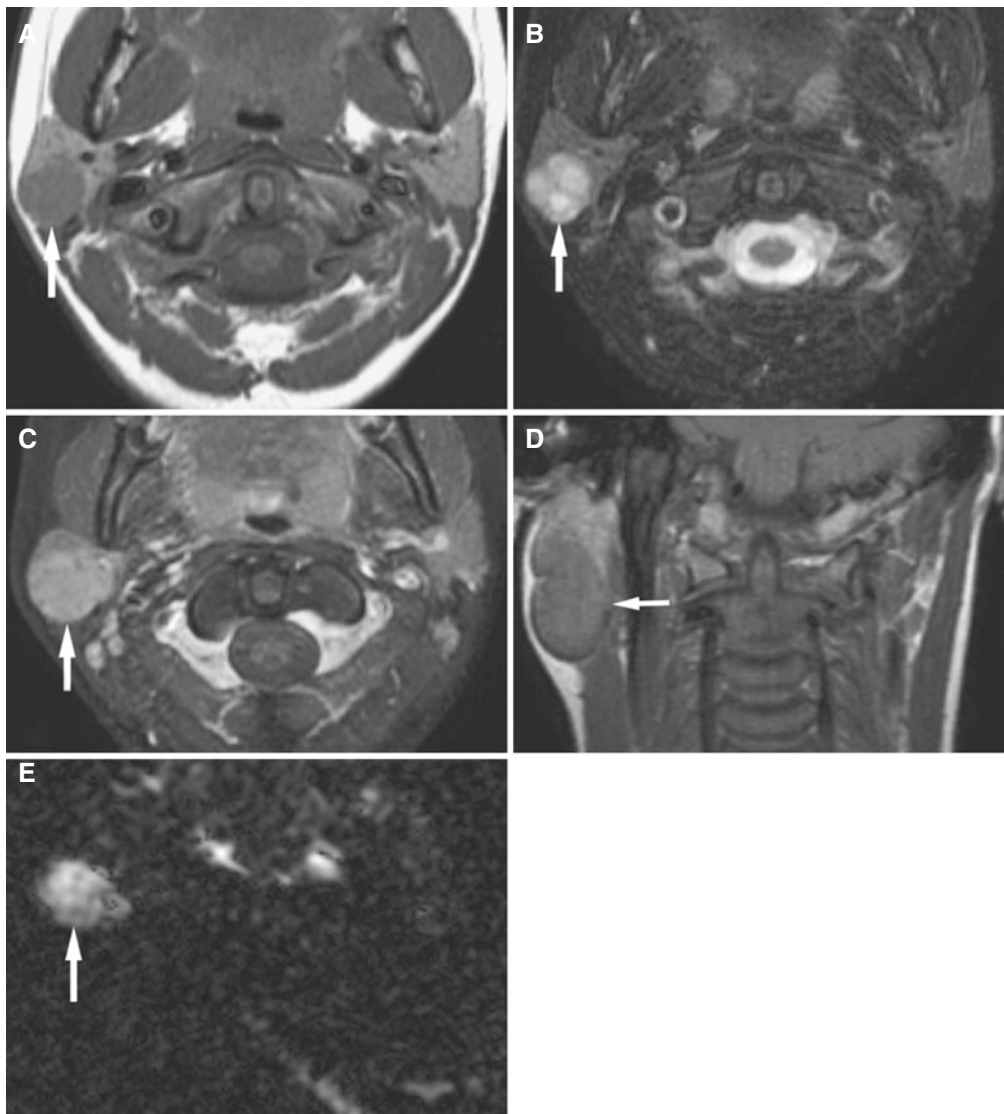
Parotid acinic cell carcinoma; 11-year-old female with painless swelling of the right parotid gland that did not respond to antibiotic treatment. (A) Axial T1-weighted MRI shows well-defined low-to-intermediate signal mass in the posterior portion of the right parotid gland (*arrow*). (B) Axial T2-weighted MRI shows high heterogeneous signal from well-defined mass (*arrow*). (C) Axial T1-weighted
